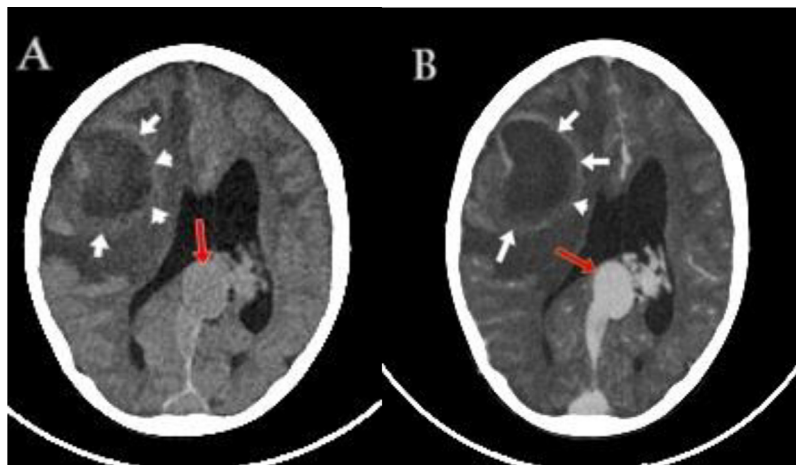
A none contrast Axial CT scan (A) and contrast-enhanced CT as in (B) shows ring enhancing right frontal peripheral cystic brain lesion (white arrows) representing *brain abscess*, surrounded by a wide area of hypodensity (edema), dilated area posterior to the third ventricle representing *aneurysm at the vein of Galen* (red arrow) as connected to straight sinus both are directly drains to the confluence of sinuses.
